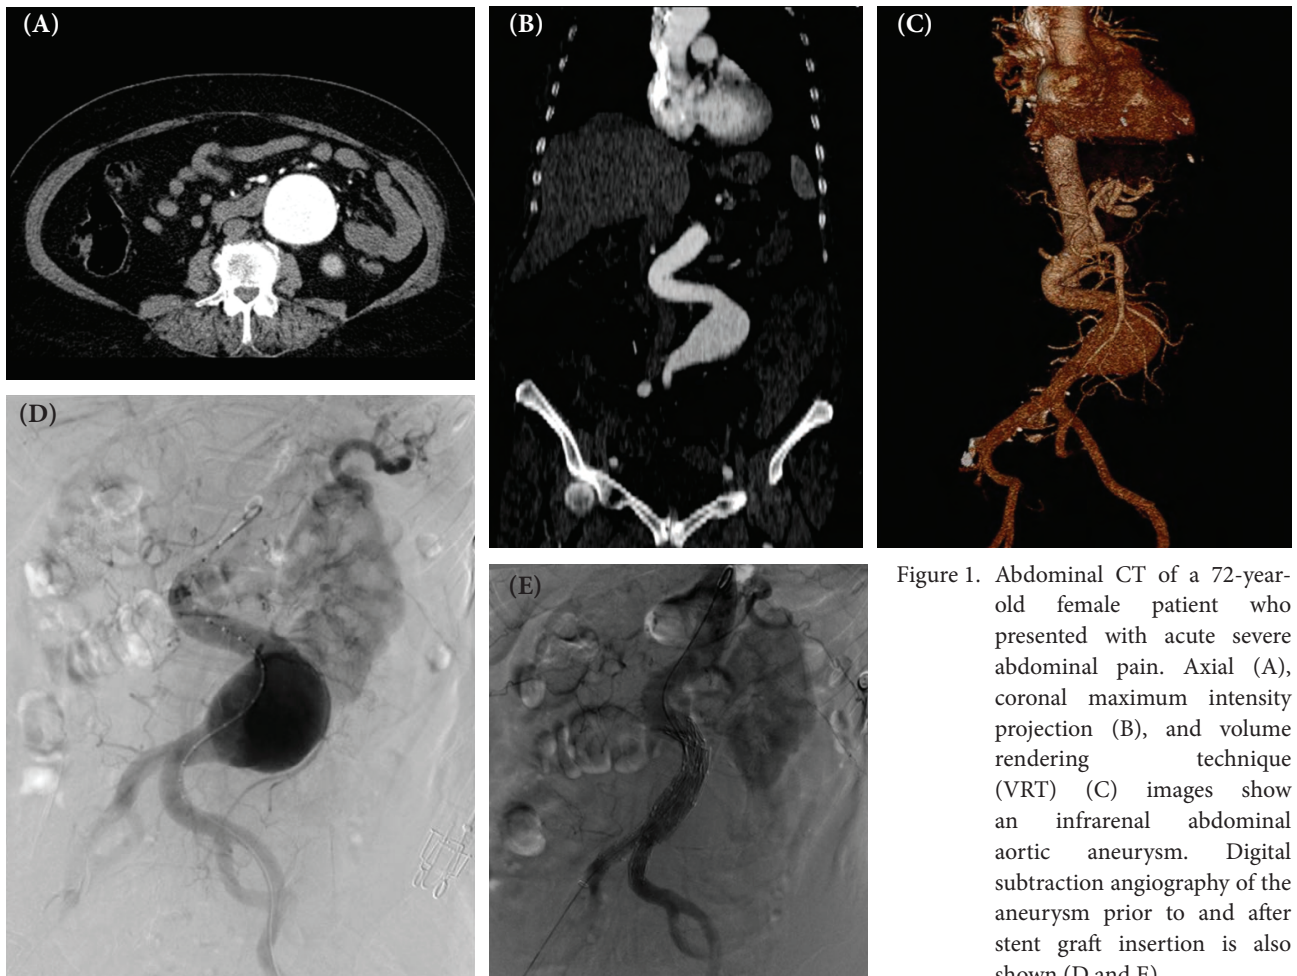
Abdominal CT of a 72-year-old female patient who presented with acute severe abdominal pain. Axial (A), coronal maximum intensity projection (B), and volume rendering technique (VRT) (C) images show an infrarenal abdominal aortic aneurysm. Digital subtraction angiography of the aneurysm prior to and after stent graft insertion is also shown (D and E).
